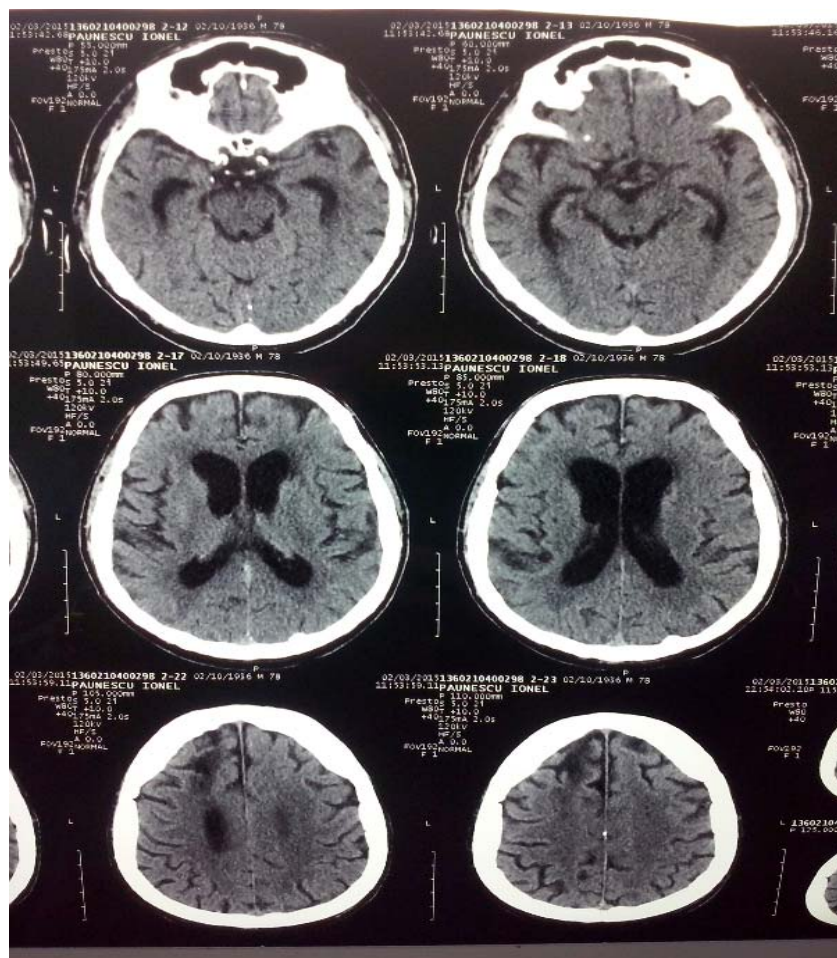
Cerebral CT scan after 14 days-Remission of right hemispheric cerebral hemorrhages.
